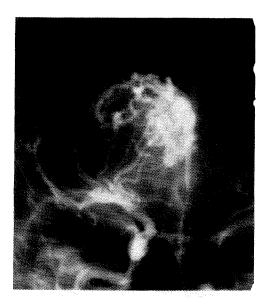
Magnified right internal carotid arteriogram showing arteriovenous malformation supplied by lenticulostriate vessels. An aneurysm on one of the feeding vessels is present. The location of the aneurysm correlates well with the site of hemorrhage detected on CT scan.
